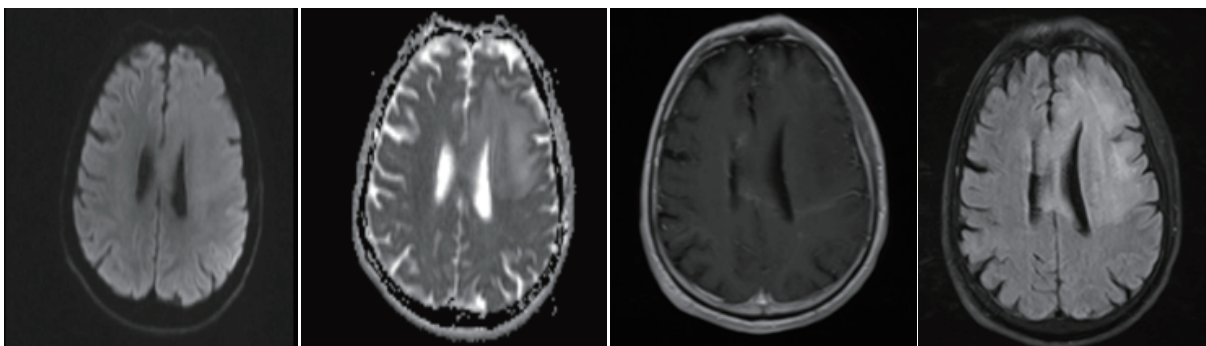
First brain MRI images of case 1, more prominent on the left in diffusion, hyperintense in bilateral diffusion, isohyperintense in ADC, hyperintense lesion on the left in FLAIR section without significant contrast uptake
